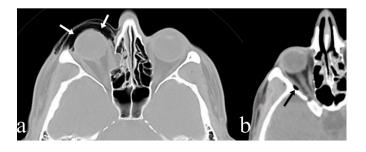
Computed tomographic images demonstrate preseptal (a: white arrow) and extraconal (b: black arrow) emphysema.
